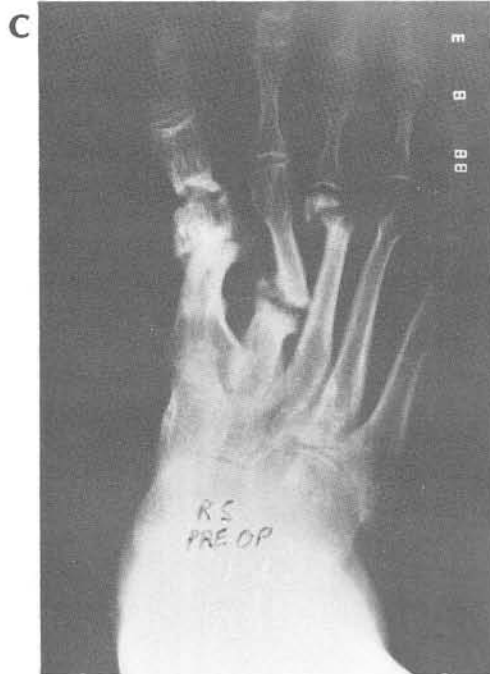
C. Initial radiographs reveal multiple nonunion sites on right foot including first, second, and third metatarsals. Significant joint destruction is also noted at medial three metatarsophalangeal joints.
